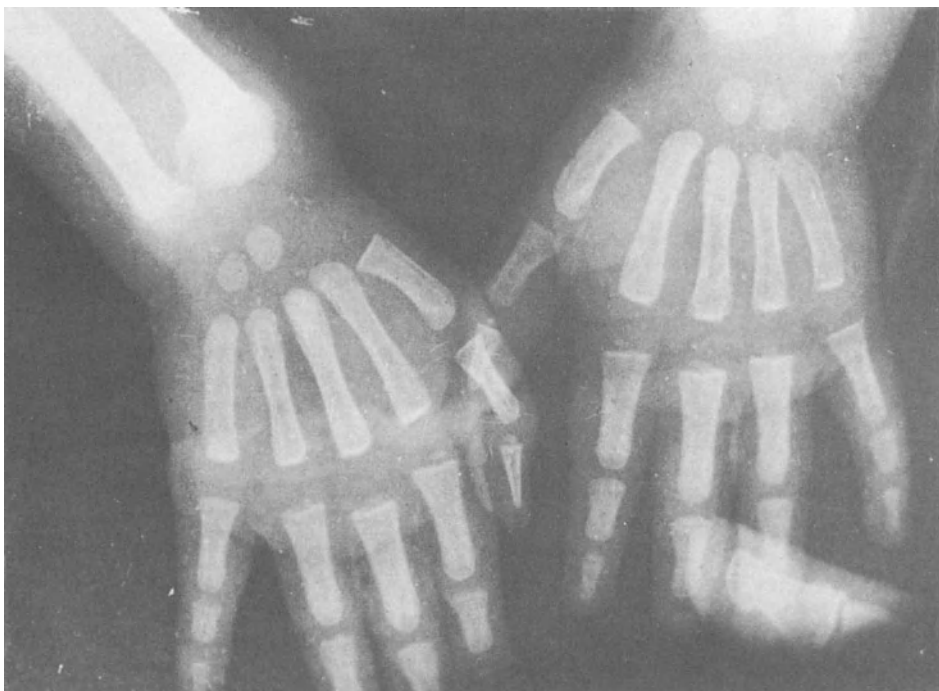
Bone x-rays showing bowing and distal thickening compatible with rickets.
